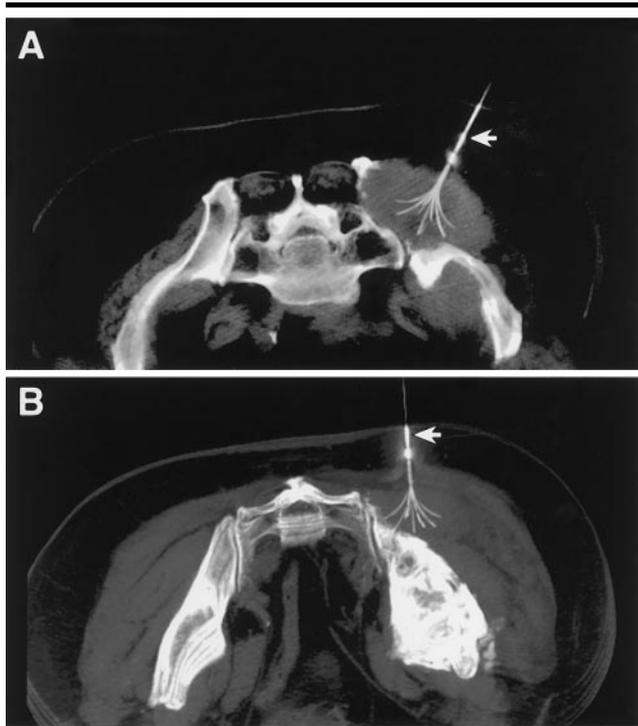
Patient 11. Transverse three-dimensional volume CT images obtained at the level of the sacrum with the patient prone show a percutaneously placed RF electrode (arrows) deployed in an osseous and soft-tissue renal cell carcinoma metastatic lesion diffusely involving the left iliac bone (A) and in a soft-tissue lesion involving gluteal musculature of the left buttock (B). The soft-tissue lesion corresponded to the site of patient's greatest pain. Before RF ablation, the average pain score was 5. At both 4 and 6 weeks after ablation, the average score was 0. This patient died 7 weeks after RF ablation, with no pain at the treated site.
